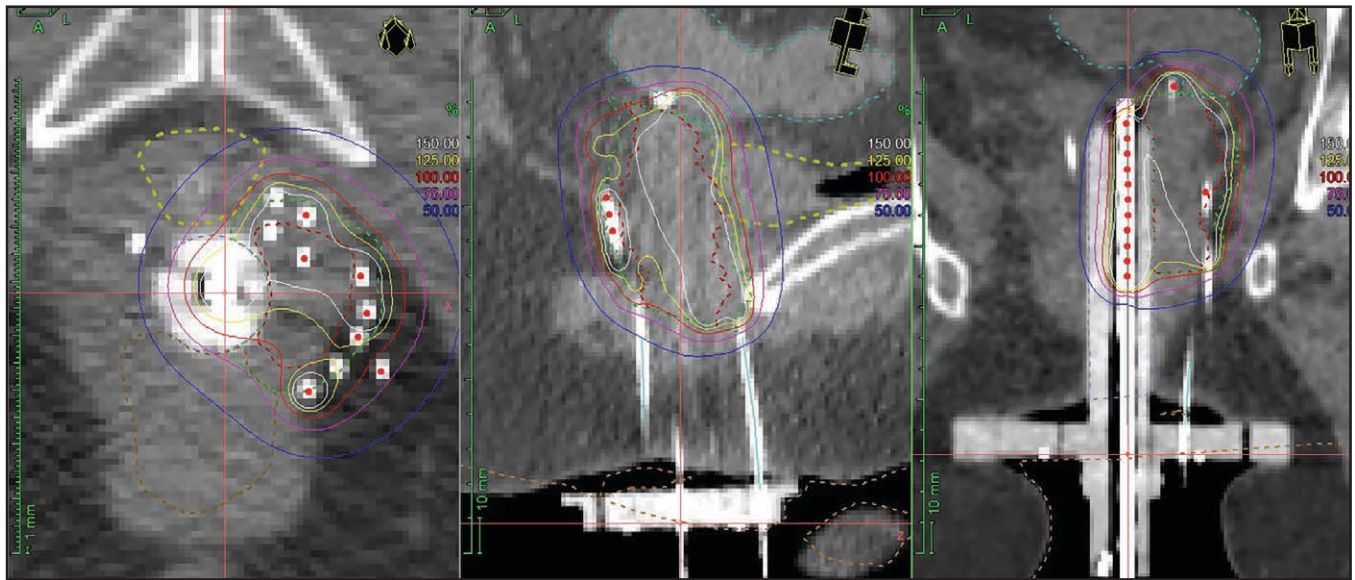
Syed 3 interstitial applicator using CT-based planning for vaginal cuff recurrence from endometrial cancer.
